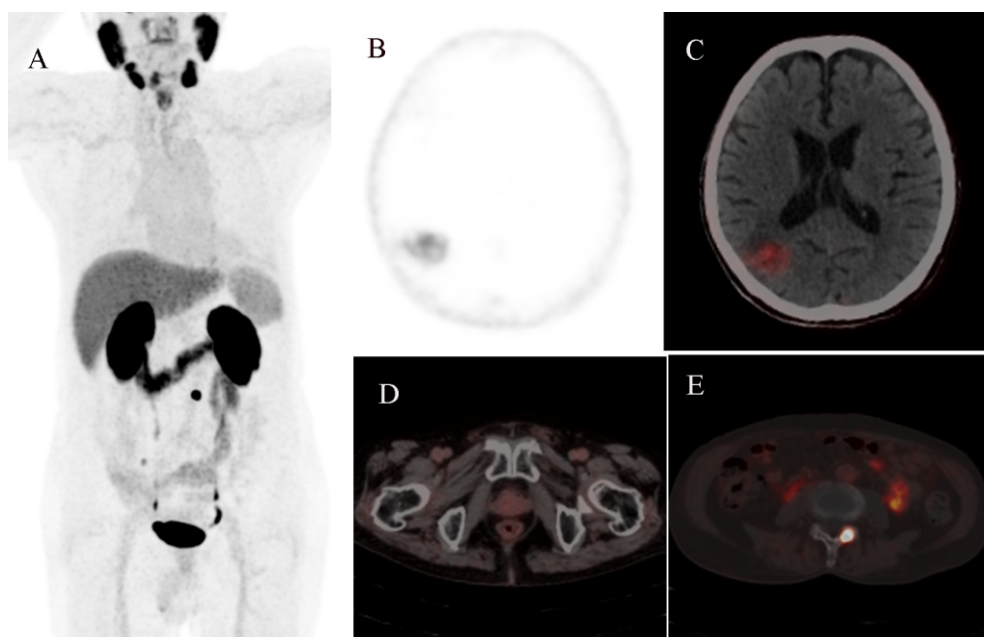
The PET MIP image demonstrates physiological uptake in the bilateral parotid glands, submandibular glands, kidneys, and portions of the intestinal tract. A focal nodular lesion with increased uptake of the imaging agent is observed in the central lower abdomen (A). Axial PET and fused PET/CT images reveal patchy increased PSMA radiotracer uptake in the right occipital lobe, with a maximum SUV of 2.7 (B-C). No PSMA increase was seen after prostate cancer treatment on axial fusion PET/CT imaging (D). Focal PSMA uptake was observed in the left pedicle plate of the L3 vertebra, suggesting a metastatic tumor (E).
